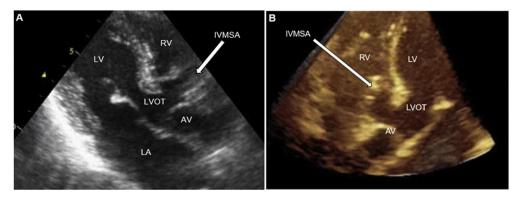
(A) Two-dimensional TTE, apical three-chamber view in diastole. (B) Three-dimensional TTE, apical five-chamber view in diastole. The *arrow* points to the pathologic outpouching from the LVOT later demonstrated to be an IVMSA. *AV*, Aortic valve; *LA*, left atrium; *LV*, left ventricle; *RV*, right ventricle.
